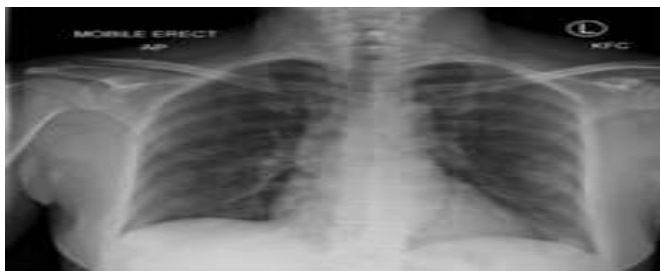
Covid-19 positive X-ray Image
